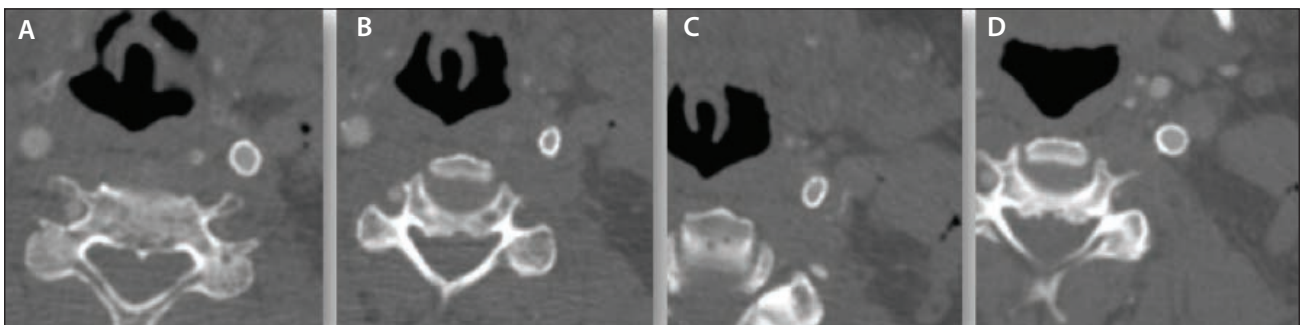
Postoperative CTA demonstrating stent patency from proximal (A) to distal (D).
